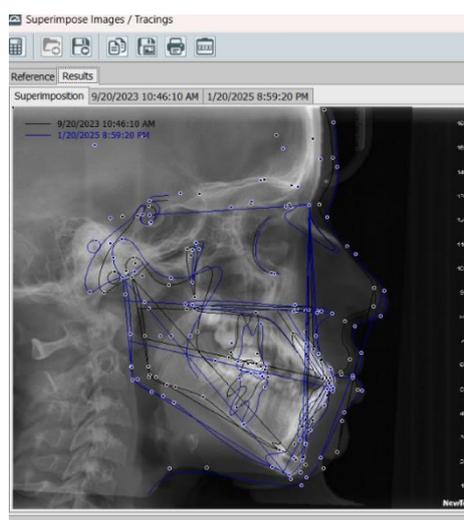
Onyxceph software used in cephalometric x-rays superimposition and measurements.
